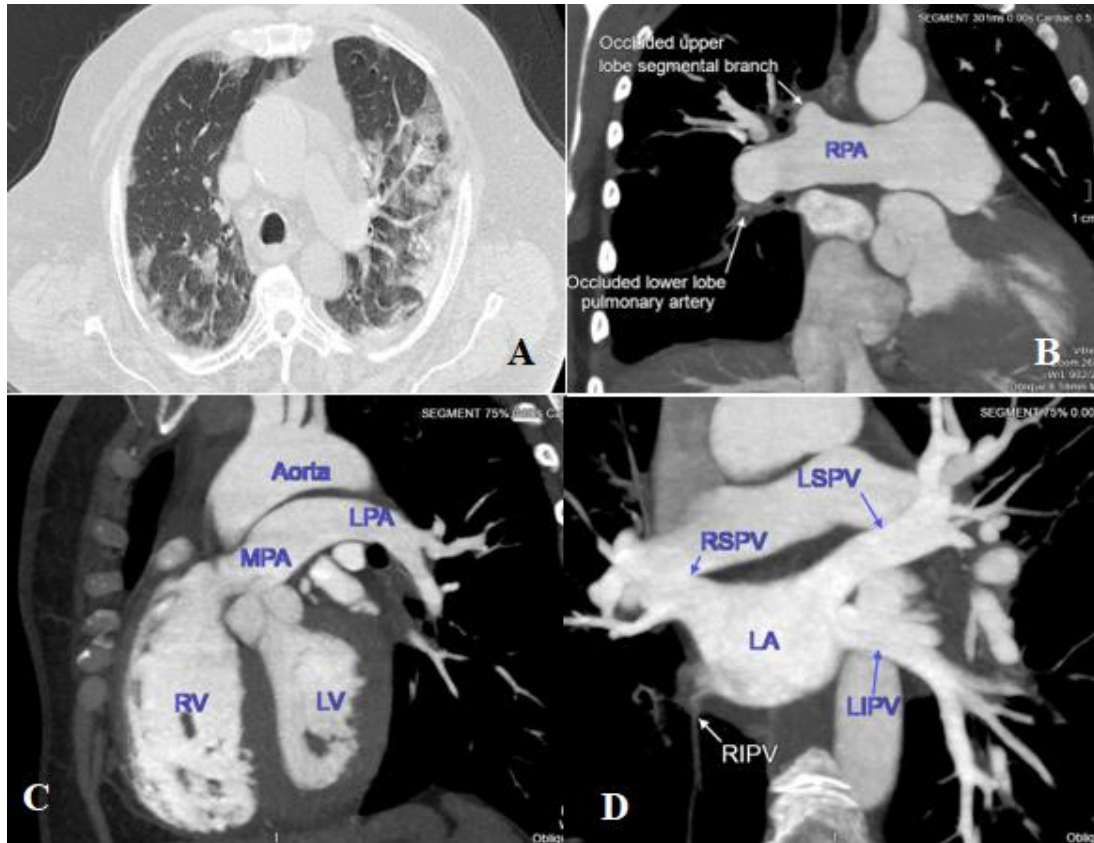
Female patient aged 35 years with CT chest findings (CORAD 5) and severity score = 22; after 10 days, the patient is complaining from chest pain and dyspnoea. D-dimer test was 700 ng/ml A) CT of the chest shows bilateral peripheral patches of ground glass opacities with bilateral areas of subsegmental consolidation of subpleural distribution, interstitial thickening and fibrotic bands with severity score 22, B) Maximum intensity projection (MIP) image showing occluded lower lobar and upper lobar segmental branches of the right pulmonary artery, C) MIP image showing Totally occluded lateral basal segmental branch of left lower lobe pulmonary artery, D) MIP image showing Occluded right inferior pulmonary vein. . Diagnosis: Bilateral pulmonary arterial emboli at lobar, segmental, subsegmental levels and occluded right inferior pulmonary vein.
